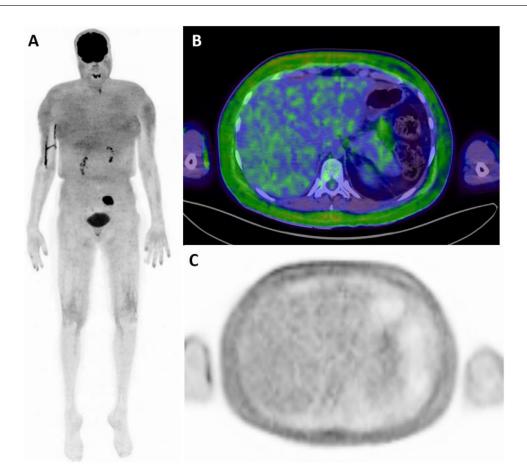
Initial staging FDG PET/CT scan. Images obtained 60 min after FDG was administered in the right arm. Blood glucose was 79 mg/dL at time of injection. (A) Maximum-intensity projection (MIP) image demonstrated altered radiotracer biodistribution in white adipose tissue predominantly in the upper torso. (B and C) Fused PET/CT (B) and attenuation corrected PET (C) at the level of the upper abdomen demonstrated increased uptake in the subcutaneous fat.
